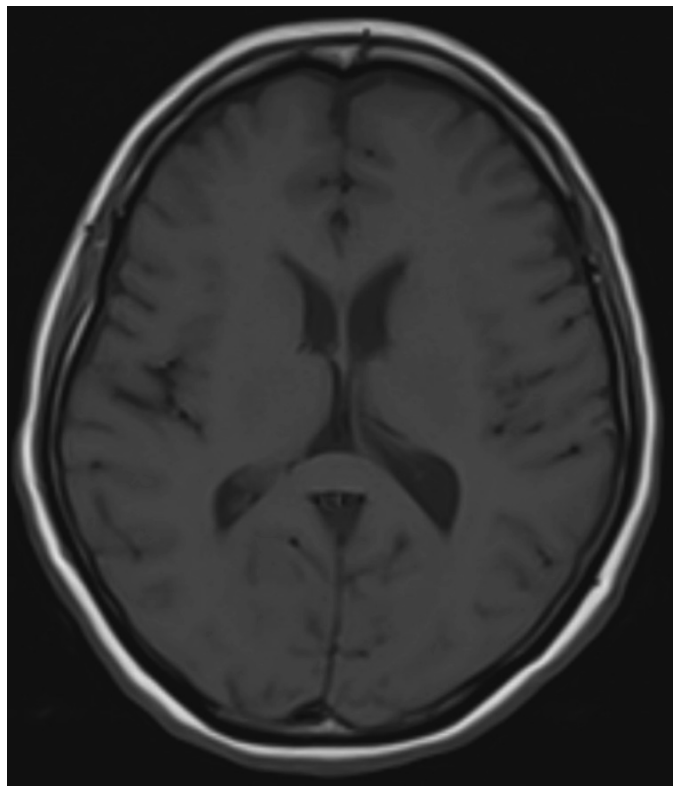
Conventional brain magnetic resonance imaging sequence
